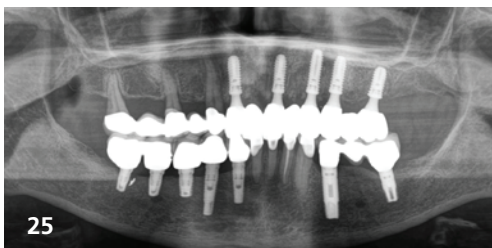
Preparation of the final intra-oral scan with scan bodies at abutment level. Figs.25: Radiographic control of the mock-up during the prosthetic phase. Fig.26: Definitive restoration. Analogous shaping of the soft tissue and bridge pontics.
